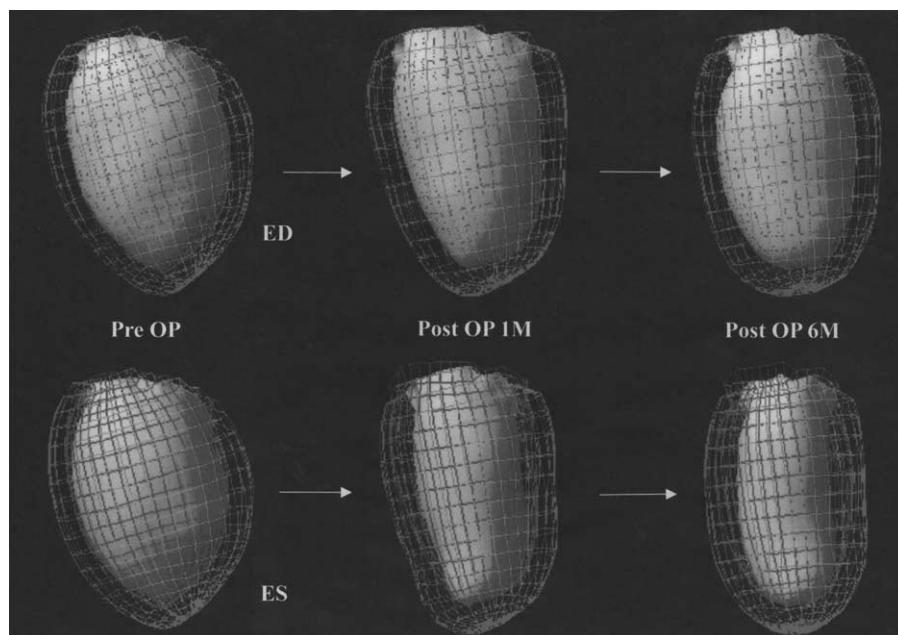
The change in left ventricle volume and shape is shown by gated single photon emission computed tomography quantification. The upper line of images shows the end-diastolic phase (ED), and the lower line of images shows the end-systolic phase (ES). The shape of the left ventricle changed from spherical to spindle at 6 months after operation. *Pre OP*, Before surgery; *Post OP*, after surgery.
